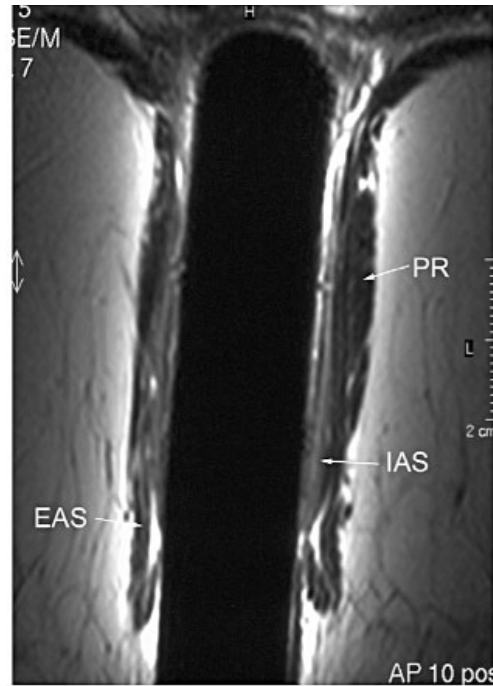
Mid coronal MRI with an endocoil. The endocoil causes the central black void from absent signal. The smooth muscle of the IAS is of moderate signal intensity, and higher than the striated muscle of the PR and EAS. Note how well the striated muscle is demarcated by the high signal from the fat in the ischioanal fossae.
